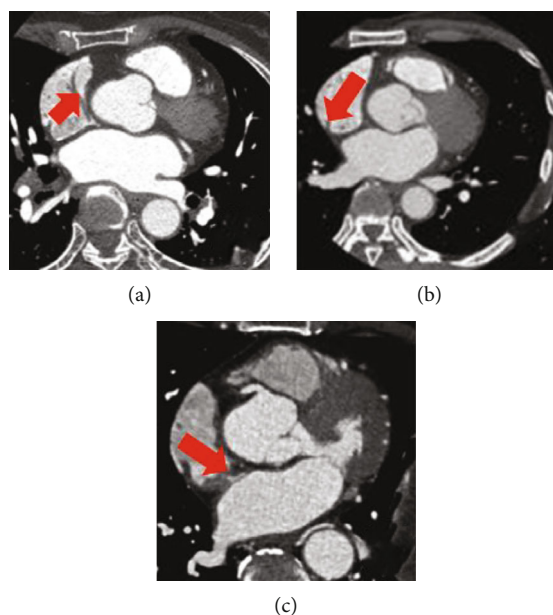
Multislice spiral CT image of a heart disease patient.
